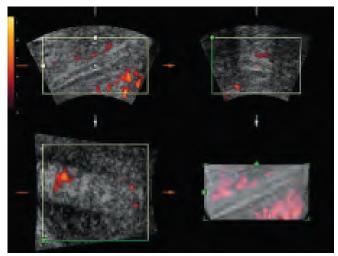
Three-dimensional power Doppler of the endometrium. Subendometrial flow reflects the degree of endometrial perfusion and may be used as a noninvasive assay of uterine receptivity
